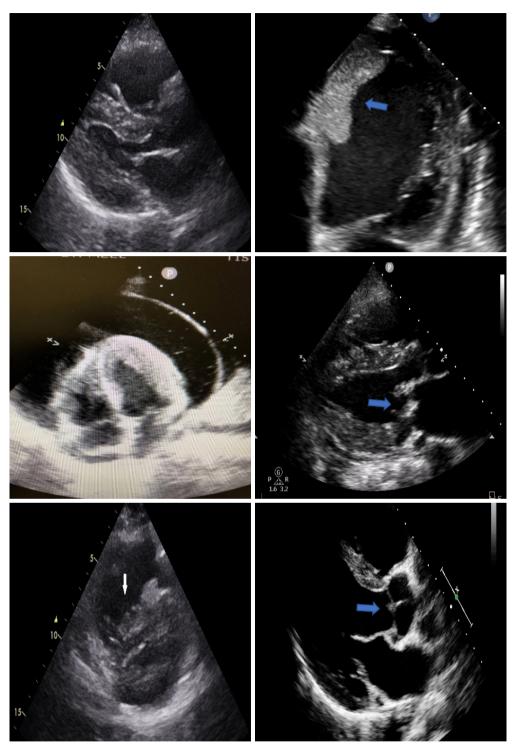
Echocardiographic images of patients with COVID-19 and cardiac disease. Top panel: patient with left ventricular hypertrophy and enlarged right ventricle (left) and dilated left ventricle (right). Middle panel: patient with pericardial effusion and tamponade (left) and rheumatic heart disease of the mitral valve (arrow) (right). Bottom panel: patient with severe pulmonary hypertension and reverse Berenheim effect (arrow) (left) and aortic valve infective endocarditis complicated by root abscess (arrow) (right).
